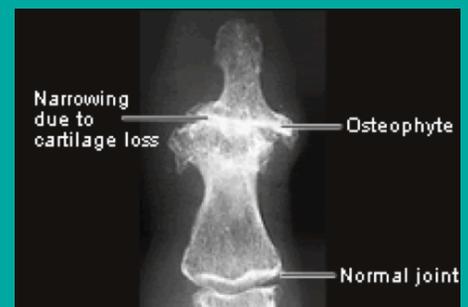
An x-ray showing the finger of a person with nodal osteoarthritis
